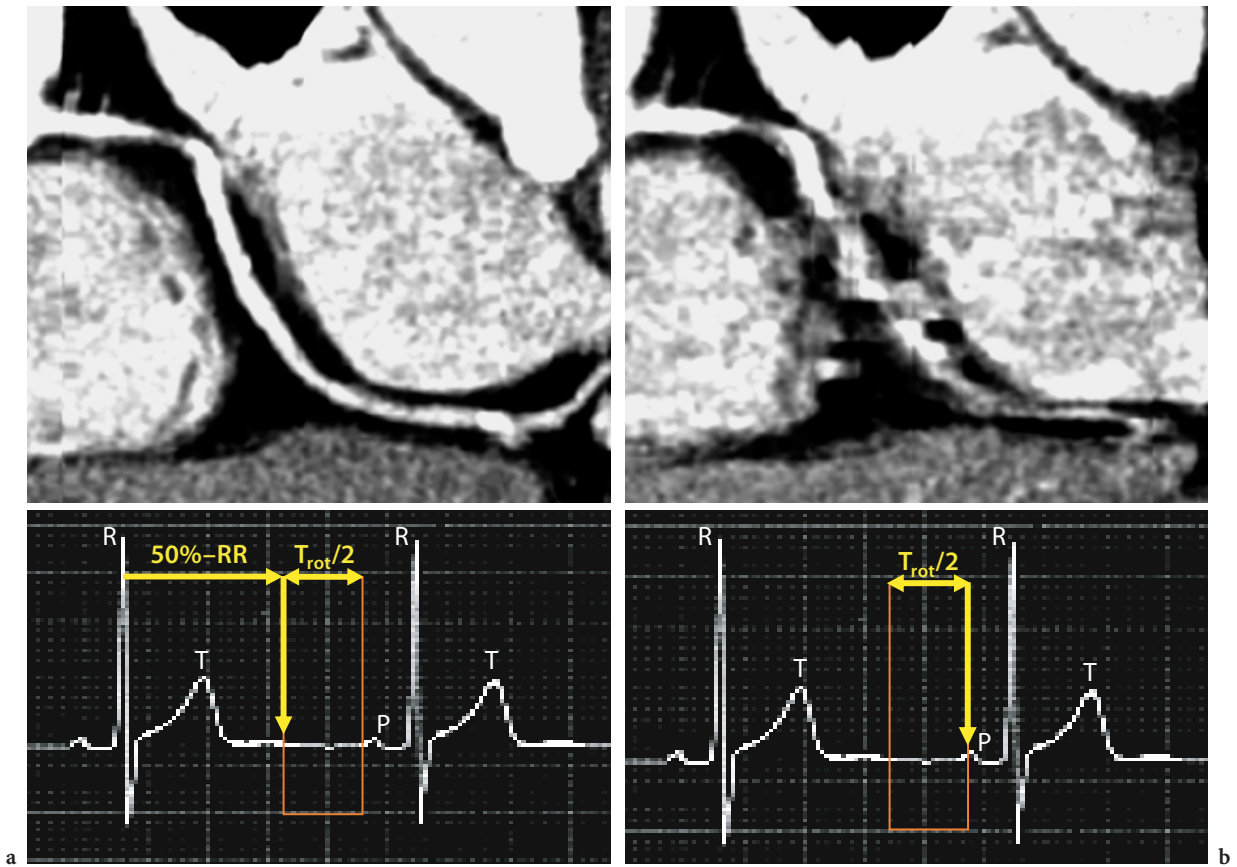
Cardiac image quality obtained by a 4-slice CT scanner with 0.5-s rotation time in end-diastole based on R-wave- and P-wave-gated image reconstruction. a During P-wave gating, the end of the image reconstruction window is positioned on the P-wave. b During R-wave gating, the start of the image reconstruction window is positioned at 50% of the RR-interval. P-wave-gated reconstruction yields superior image quality compared to R-wave-gated reconstruction due to more consistent phase selection
